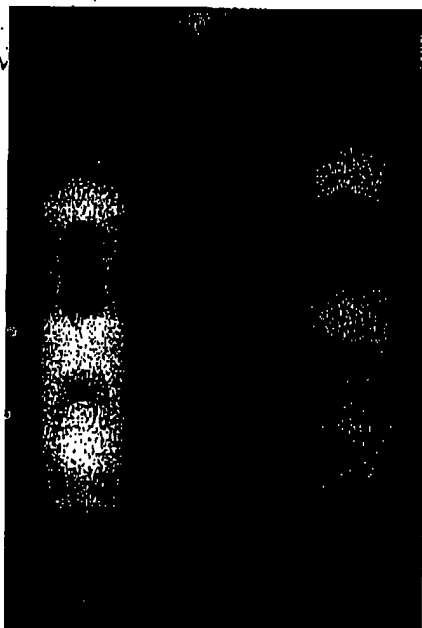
(left) Radiograph of both implants at time of insertion.
